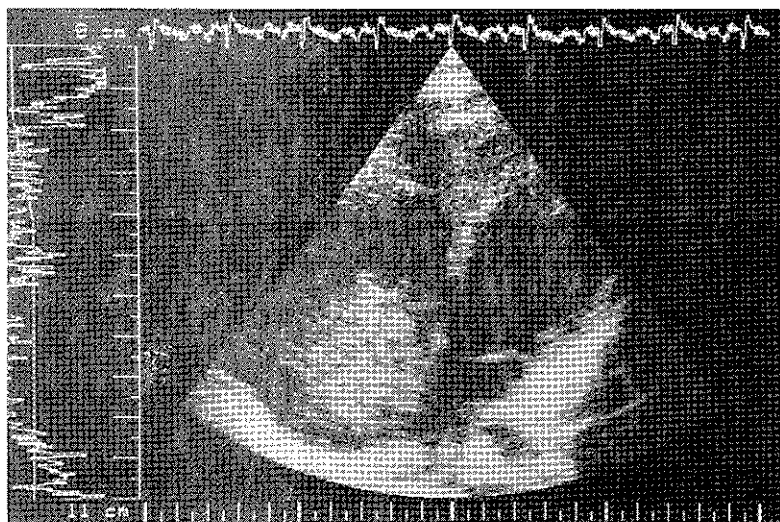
Two-dimensional echocardiogram, apical four chamber view, showing a large right atrial myxoma obstructing the tricuspid valve.
